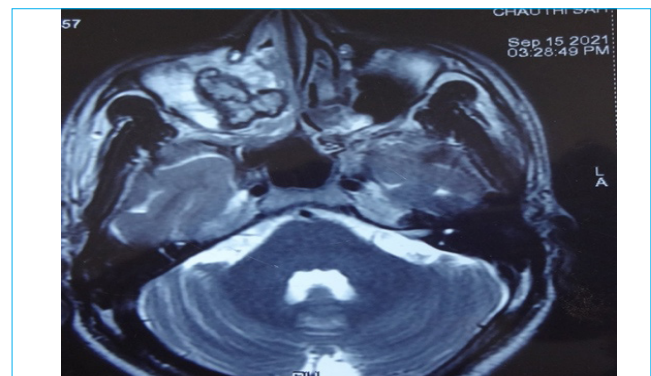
MRI of nose and PNS
